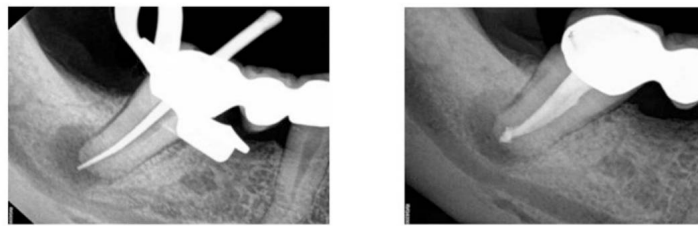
(c) Master gutta-percha cone radiograph. (D) Final radiograph showing dense obturation.
